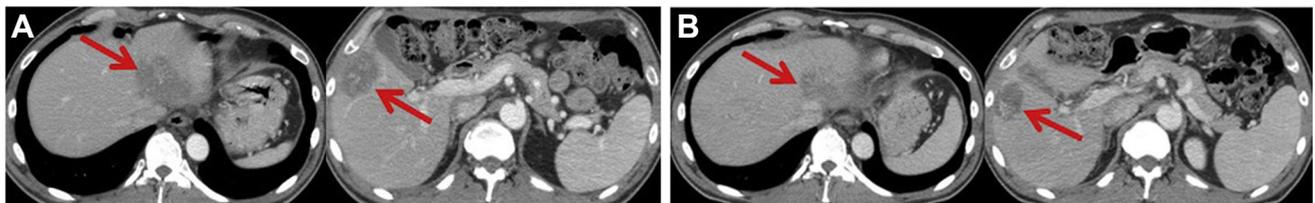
Patient with metastatic colorectal cancer—Pretreatment CT (A). Axial contrast-enhanced CT images through the level of the liver demonstrate two large lesions involving the right and left lobes of the liver (red arrows). Posttreatment images (B): Axial contrast-enhanced CT images through the level of the liver demonstrate significant decrease in the size of the two large lesions involving the right and left lobes of the liver (red arrows).
